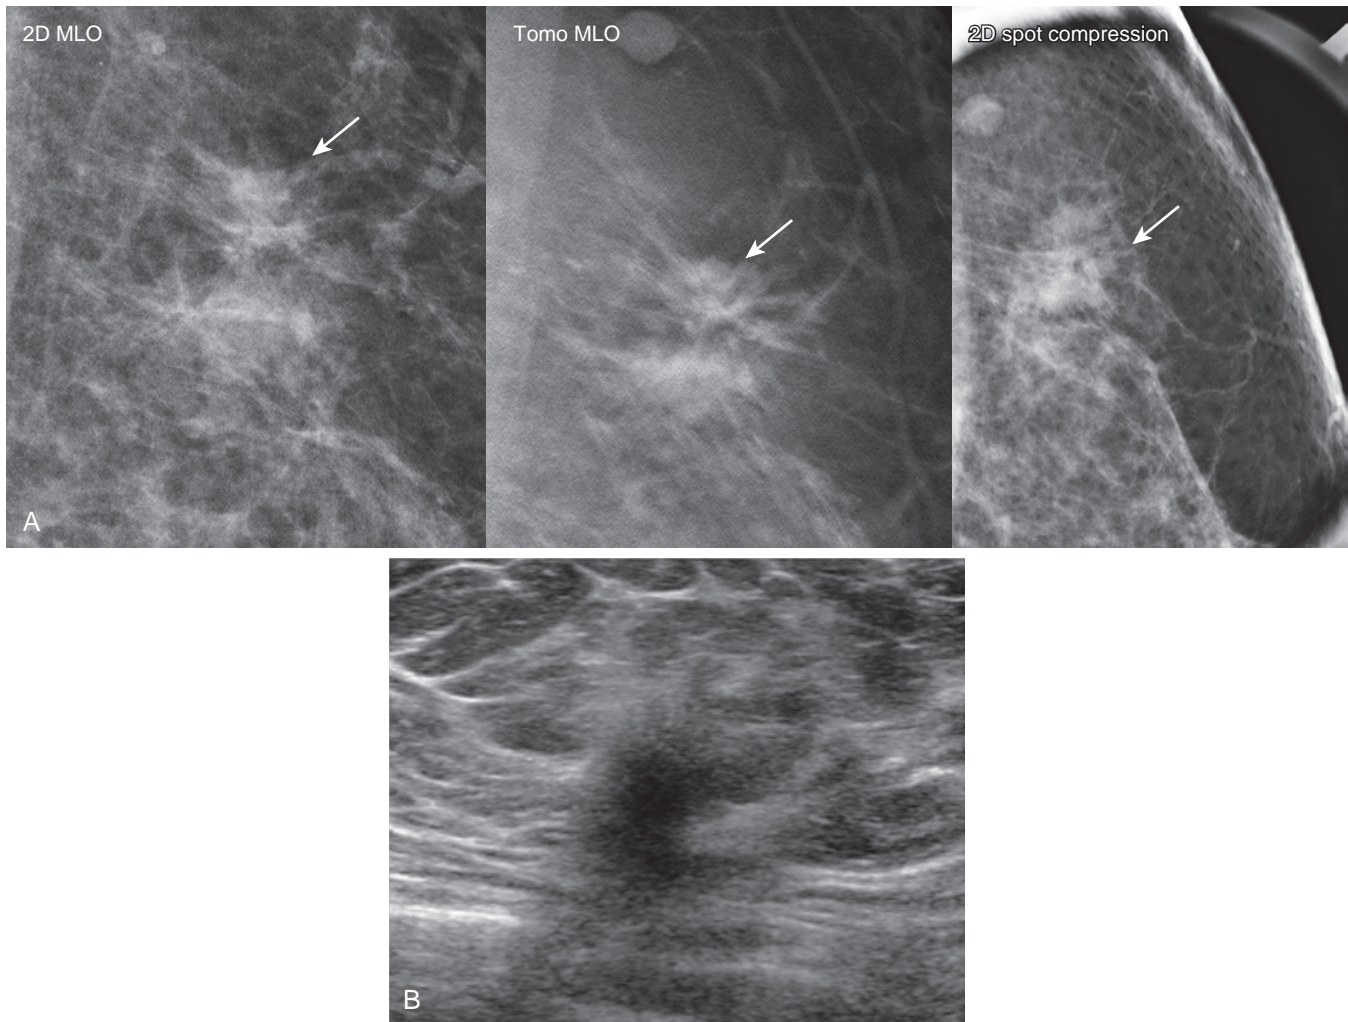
Invasive ductal cancer best seen on tomosynthesis (A) Baseline screening mammogram in a 40-year-old woman shows a focal asymmetry (*arrows*) in the left superior lateral breast. The underlying mass and spiculated margins are well seen on tomosynthesis. On 2D spot compression the spiculations are not obvious and the underlying mass resembles fibroglandular tissue. (B) Targeted ultrasound demonstrates a corresponding irregular, taller-than-wide hypoechoic mass with angular and indistinct margins. Ultrasound-guided core needle biopsy and surgical excision revealed well-differentiated invasive ductal carcinoma, ER/PR+, Her2-, 0/1 SLN.
